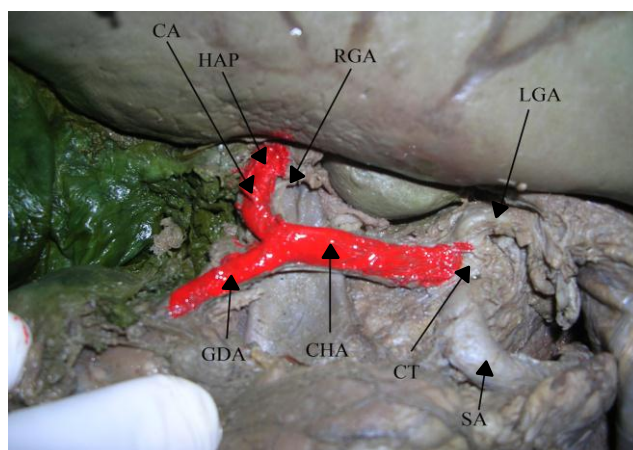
Classic textbook pattern of common hepatic artery (CHA). Right hepatic artery (RHA), left hepatic artery (LHA), right gastric artery (RGA), left gastric artery (LGA), splenic artery (SA) and celiac trunk (CT) are also visible. CHA and its branches are coloured red.
